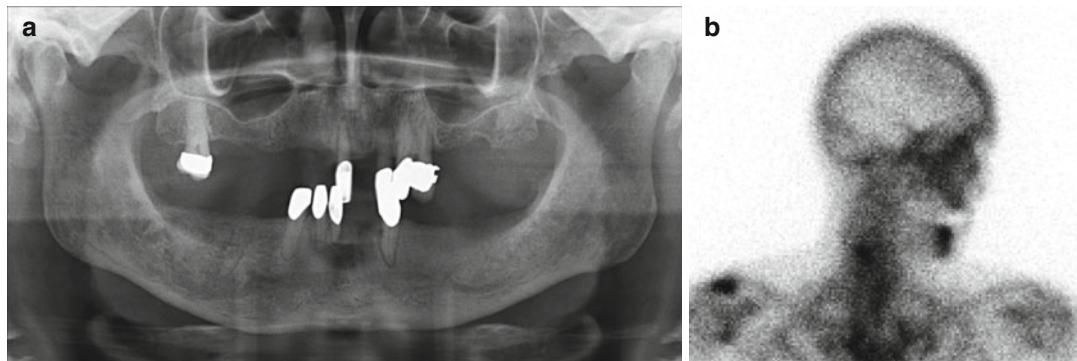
ONJ. A 60-year-old patient following BP and denosumab therapy with (a) radiographic lucency in toothless region 14 and 13 with correlating (b) scintigraphy
